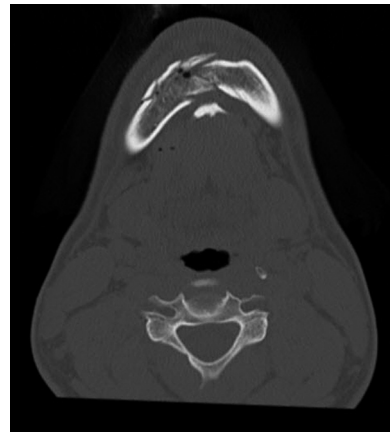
Preoperative axial CT scan to analyze the degree of comminution.
